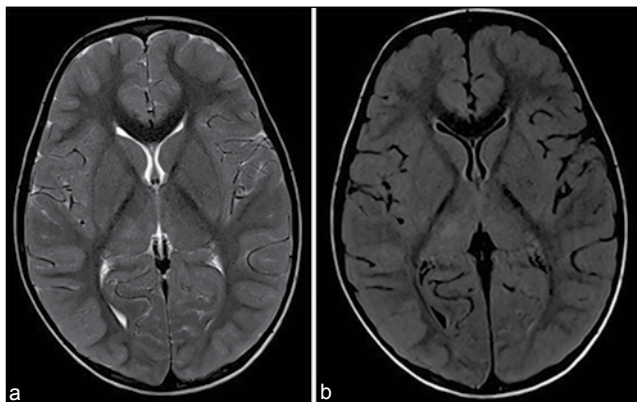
Axial T2/FLAIR MRI images reveal hyperintense lesions involving bilateral thalami (3a and b)
